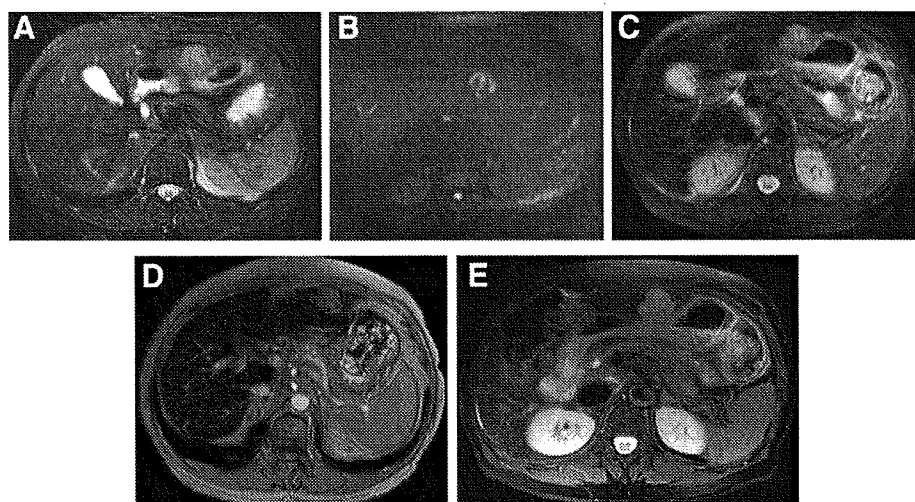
Images obtained using superparamagnetic iron oxide-enhanced (SPIO) administration obtained in a 55-year-old woman with hepatic metastasis from pancreatic cancer. Precontrast (A) fat-saturated T2-weighted TSE (5330/103), and (B) diffusion-weighted GRAPPA (2100/91; b-factor, 1000 seconds/mm²) MR images. Postcontrast (C) fat-saturated T2-weighted TSE with respiratory triggering (PACE), (D) T2*-weighted GRE (169/9, 60 degrees flip angle), and (E) fat-saturated PROPELLER T2-weighted TSE with PACE MR images. A 3-cm diameter metastasis is seen in the lateral segment of the left lobe on all images. The patient is moving during the MR examination, and the hepatic lesion is the most clearly seen and given the best motion correction on the PROPELLER MR image (E). Some differences in slice position are observed because of respiration, although images were planned for the same position. Note that the hyperintense lesions in the right lobe (A, B, D) and in segment IV (C) were confirmed to be pseudo-lesions.
